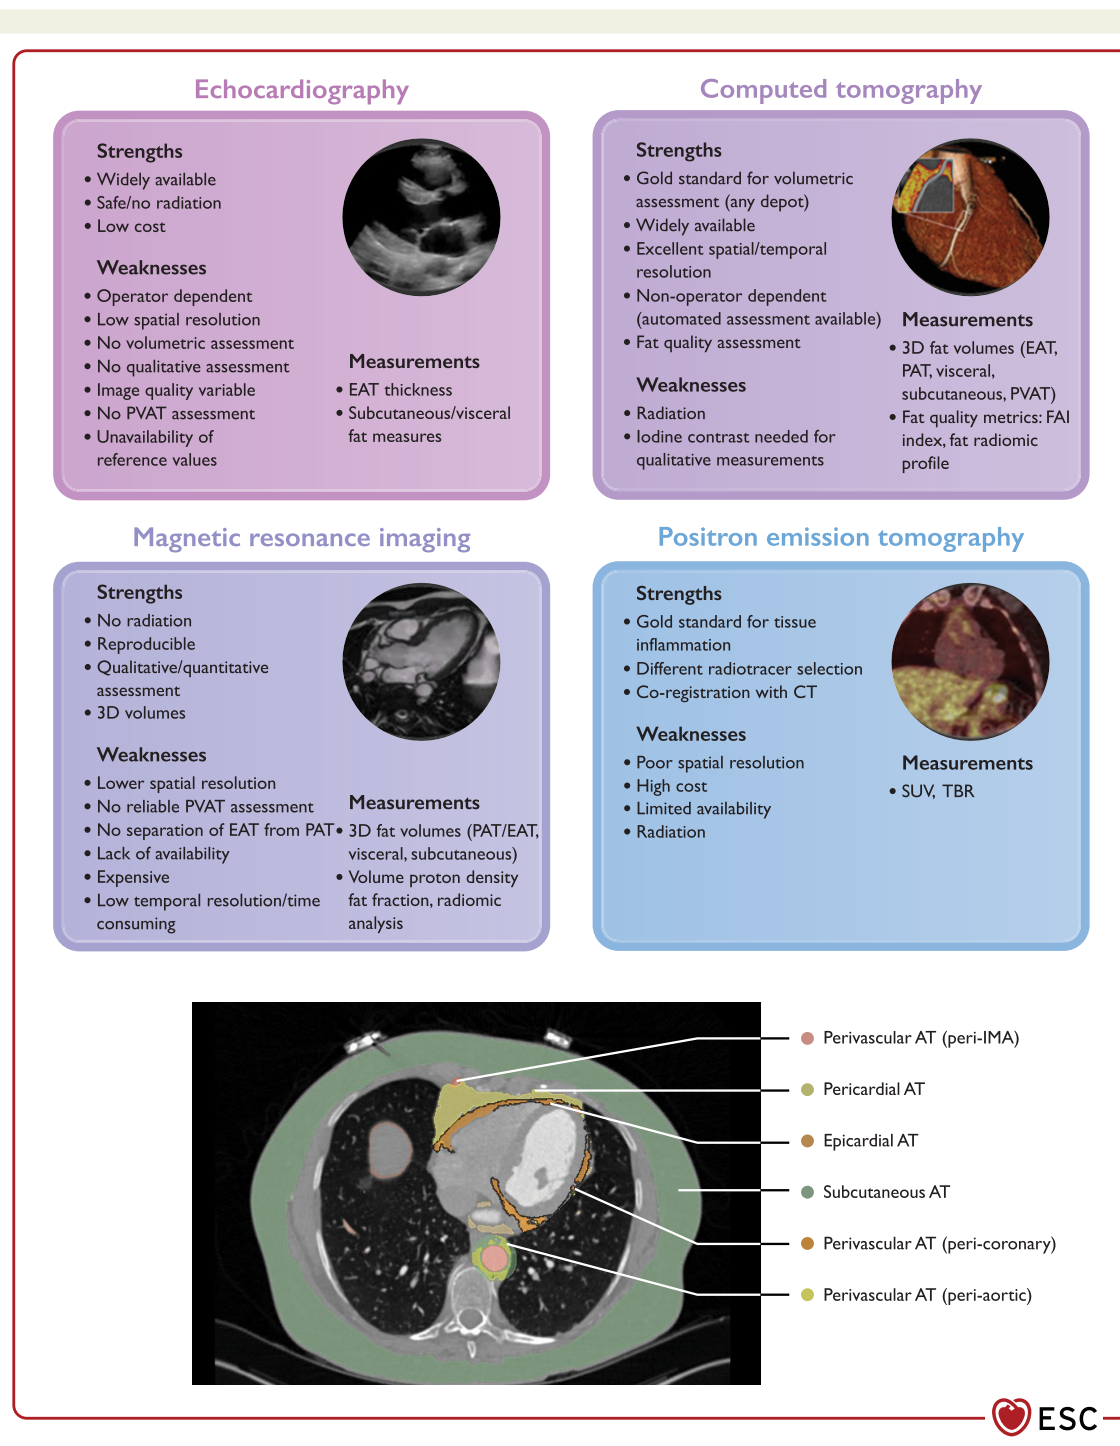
Main imaging modalities for assessment of adipose tissue. Upper part: Comparison of different imaging modalities for assessment of adipose tissue. Lower part: Distribution of adipose tissue around the heart. Axial view of the chest in computed tomography, showing subcutaneous, visceral abdominal, thoracic (including the pericardial and epicardial) adipose tissue. Perivascular adipose tissue is defined as the adipose tissue lying within a radial distance from the outer vessel wall equal to the vessel diameter (or at a maximum distance of 2 cm in the case of large vessels with diameter >2 cm, like the aorta). 3D, three-dimensional; CT, computed tomography; EAT, epicardial adipose tissue; PAT, pericardial adipose tissue; PVAT, perivascular adipose tissue; FAI, fat attenuation index; IMA, internal mammary artery; AT, adipose tissue; SUV, standardized uptake value; TBR, target-to-blood pool ratio. Modified from Antoniadou et al.⁴⁴
